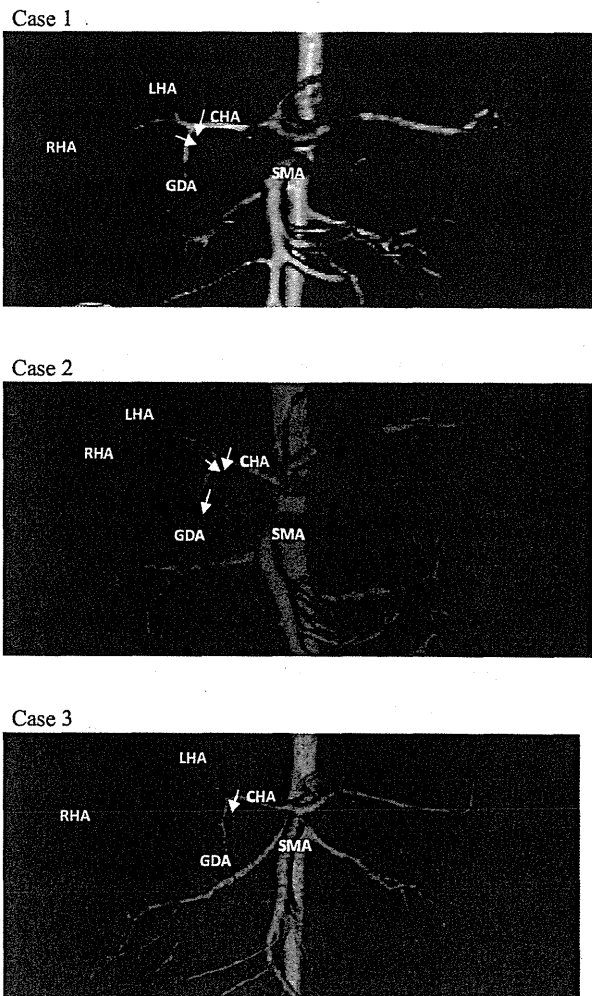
Three cases of HAs according to the 3D-CT findings in the first recipient. Arrows denote the sites of dissecting.
